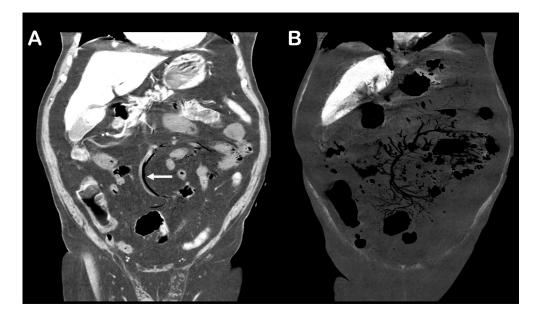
(A) CT coronal image in the portal phase showing an extensive filling defect in SMA (white arrow), with the presence of endoluminal gas. (B) CT coronal reformatted image with minimum intensity projection (minIP) which depicts nicely the tree-like distribution of gas in SMA and its collaterals.
